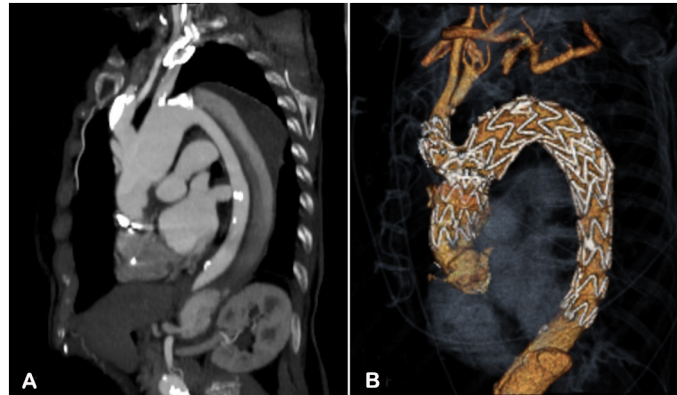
CTA showing an acute TBAD in a highly angulated type III aortic arch with no adequate sealing zone in zone 1 or 2, and requiring an extensive coverage of the aortic arch with a proximal landing zone in zone 0 (A). Final result 3D reconstruction of the hybrid treatment with a single branched arch endograft and supra-aortic trunks debranching (right common carotid artery-left subclavian artery bypass and left common carotid artery reimplantation on the graft) (B).
